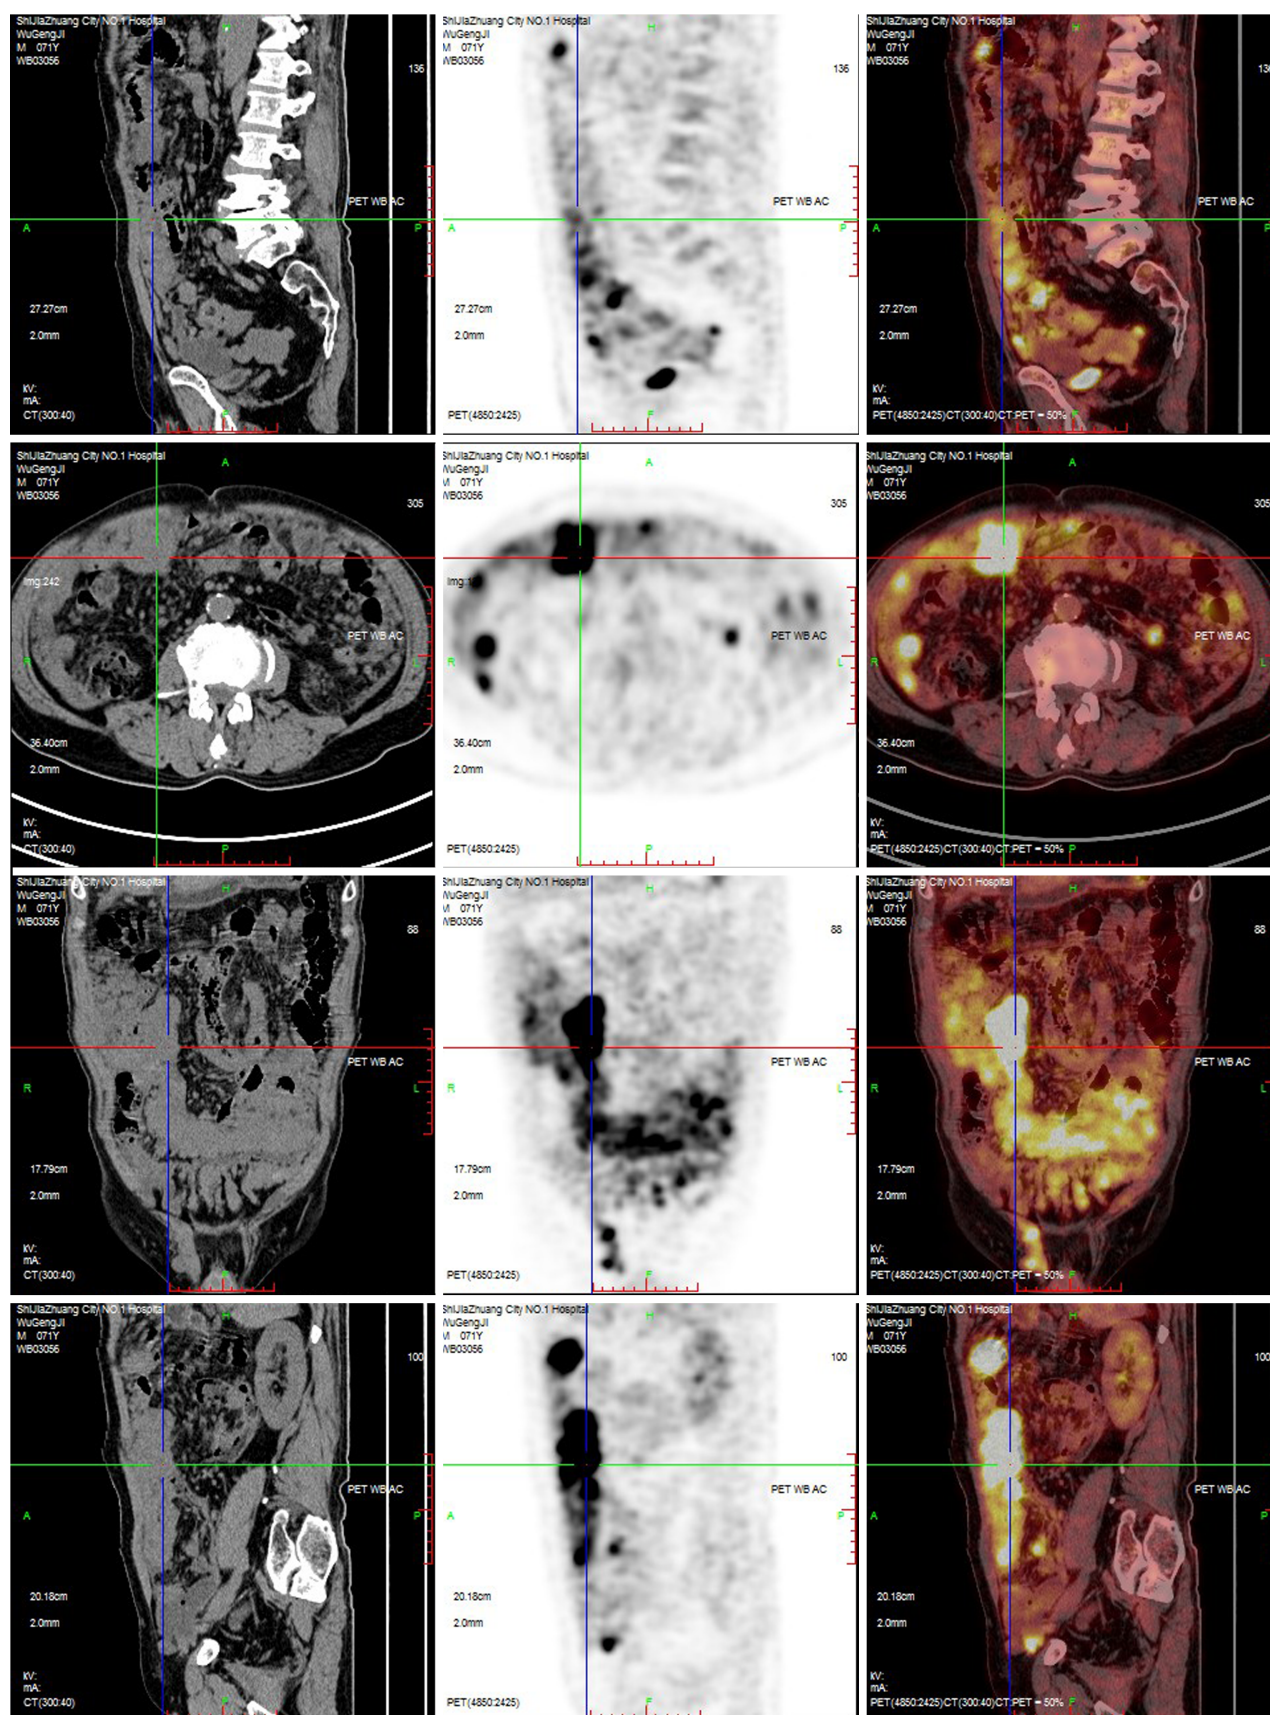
Positron emission tomography-computed tomography. It shows that the peritoneum is thickened with abnormal hypermetabolism, multiple mass or nodular soft tissue density images in abdominal/pelvic cavity and peritoneum; via enhancement scanning, the lesion is enhanced in mild to moderate level; multiple hypermetabolic lymph nodes in abdominal/pelvic cavity and right external ilium; and seroperitoneum.
